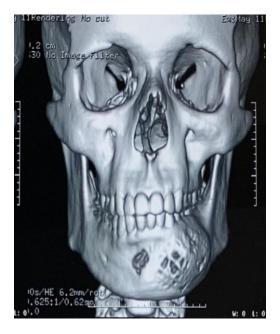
3D reconstruction image of CT showing expansile lesion extending from anterior mandible extending upto ramus of mandible at left side.
